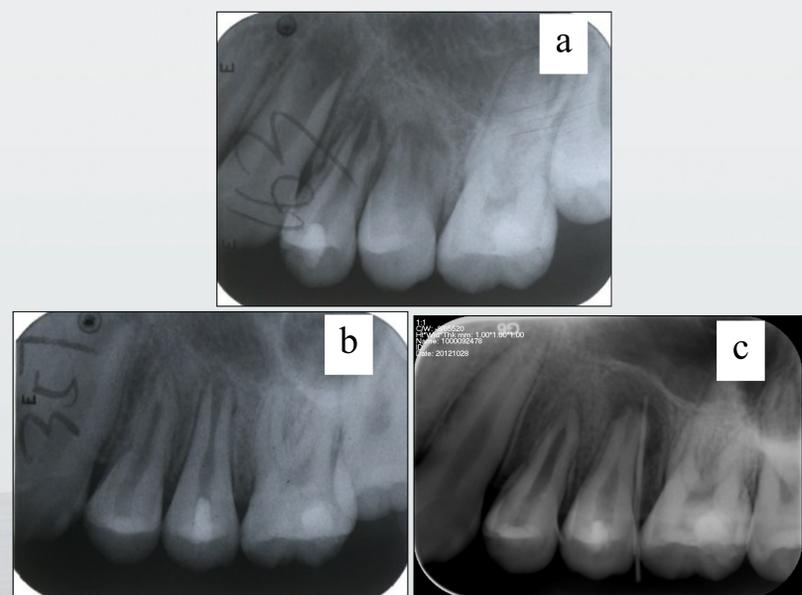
Teeth 24, 25 presented sinus tracts on their buccal gingivae and periapical radiolucency after apices were closed. (a) Preoperative radiograph. (b) Fifteen-month follow-up radiograph. (c) Forty-month follow-up radiograph showed tracing of the sinus tracts with two gutta-percha points.
